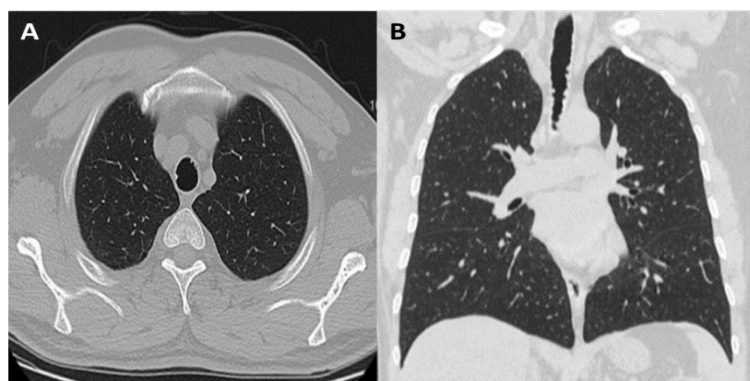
(A) Axial and (B) coronal CT images showed irregular thickening and nodularity of tracheal cartilage.
